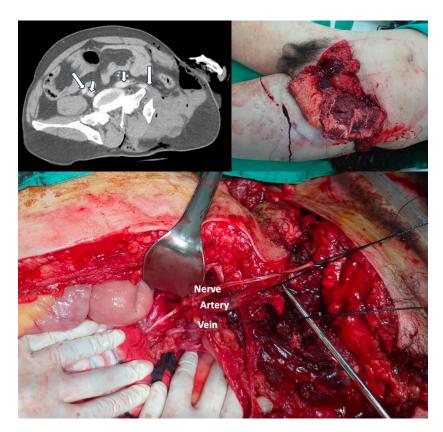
A 57-year-old male with a truncal crushing injury presented with an open pelvic fracture and injuries to the external iliac vessels, as detailed in Supplementary Table 1, patient #4. On the CT scan, short arrows point to the intact bilateral IIAs, while long arrows highlight the intact right EIA and the injured left EIA, which showed occlusion with thrombus formation. Notably, the occluded left EIA led to compensatory dilatation of the left IIA, making it larger than the right IIA. During surgery, the injured vein was ligated to achieve hemostasis, and arterial revascularization was accomplished with a graft bypass.
